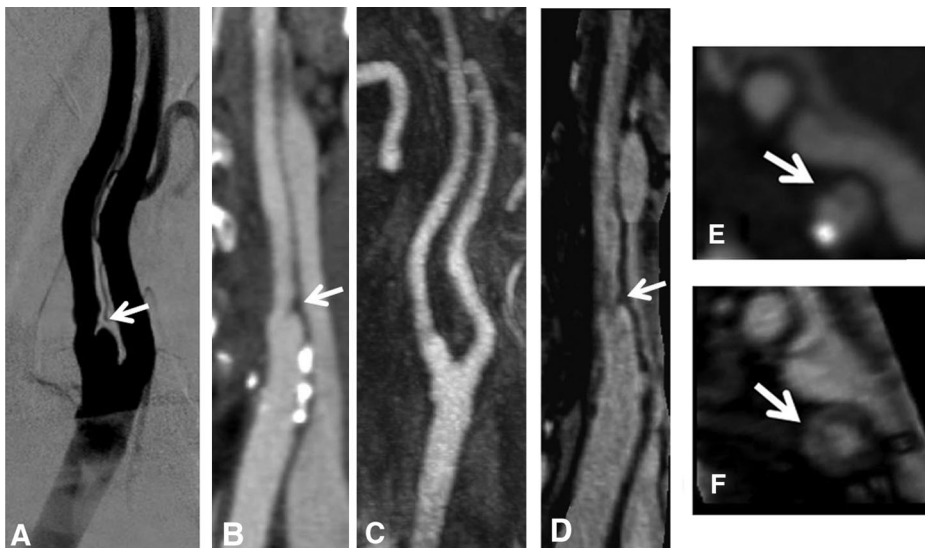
DSA (A) reveals an ulcerated plaque causing a NASCET grade II stenosis (arrows) of the left ICA. Stenosis was also reported as grade II at CTA (B), although the ulceration was barely visible. On CE-MRA FP (C) images neither the stenosis nor the ulceration was apparent. The stenosis was correctly graded at SS c-MPR (D) and the ulceration was reported in agreement with DSA. Coaxial reformations from CTA (E) and SS MRA (F) show the lumen at the point of maximum stenosis (arrows). In this case the readers assigned a score of 2 for the usefulness of the SS acquisition (SS images provide additional diagnostic information over FP images potentially or definitely impacting the final diagnosis).
